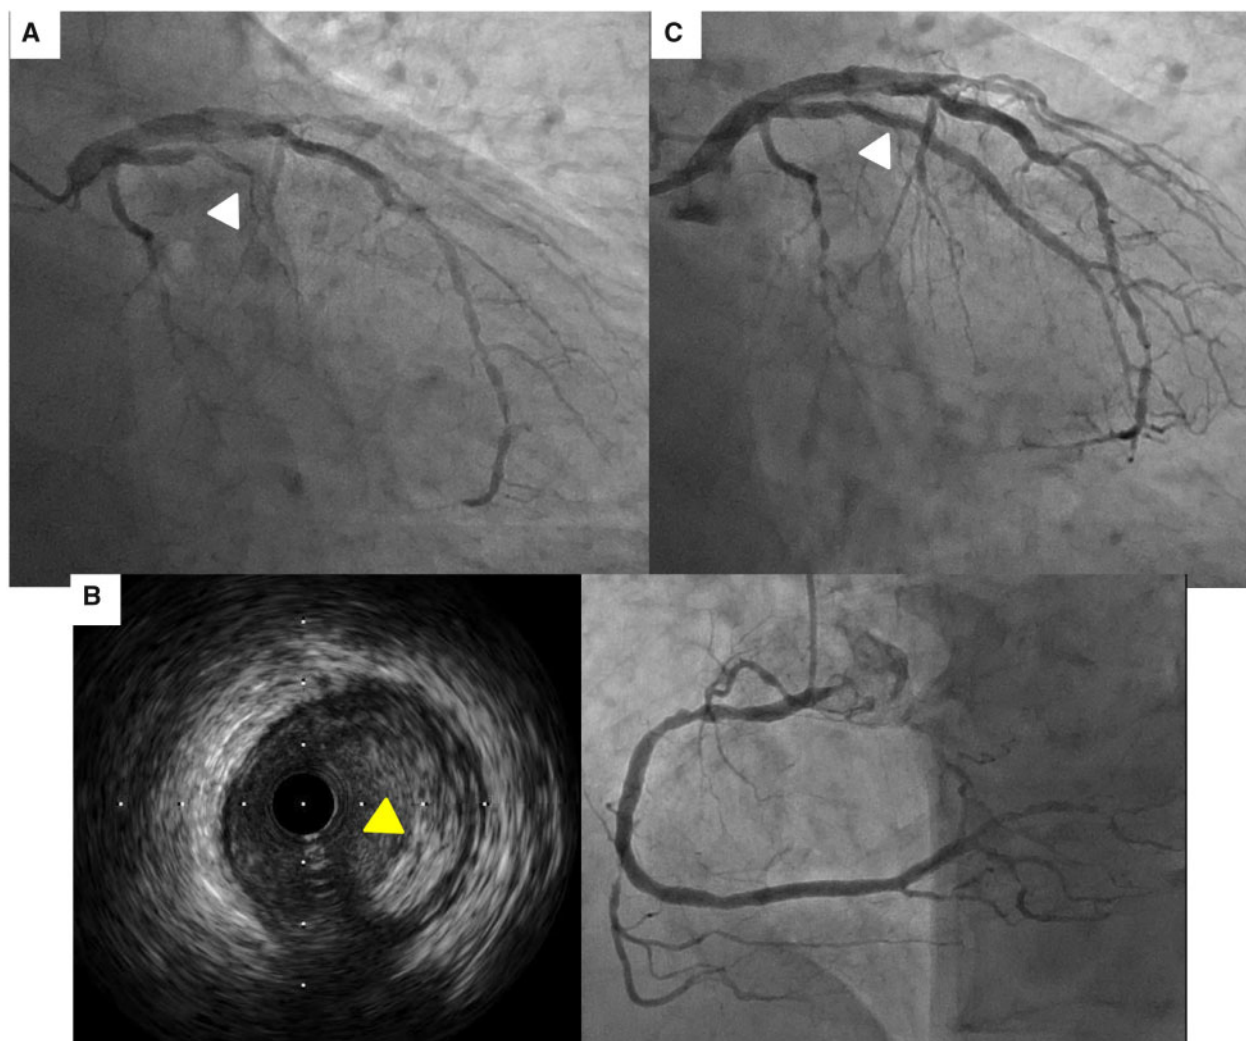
(A) Coronary angiography demonstrating atherosclerotic plaques in multiple coronary arteries and total occlusion of the obtuse marginal branch (white triangles). (B) Intravascular ultrasound after thrombectomy demonstrating atherosclerotic plaque lesions in the middle of the obtuse marginal branch. (C) Percutaneous coronary intervention was performed to the occlusion site and two drug-eluting stents were deployed, and Thrombolysis in Myocardial Infarction 3 flow was achieved.
